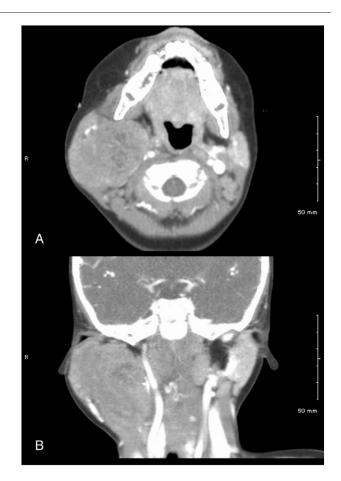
Axial (A) and coronal (B) CT images of the right parapharyngeal mass. The mass is slightly hyperintense to muscle and hypointense to the parotid gland, traversing the stylomandibular tunnel into the right parapharyngeal space. The carotid artery is displaced medially.
